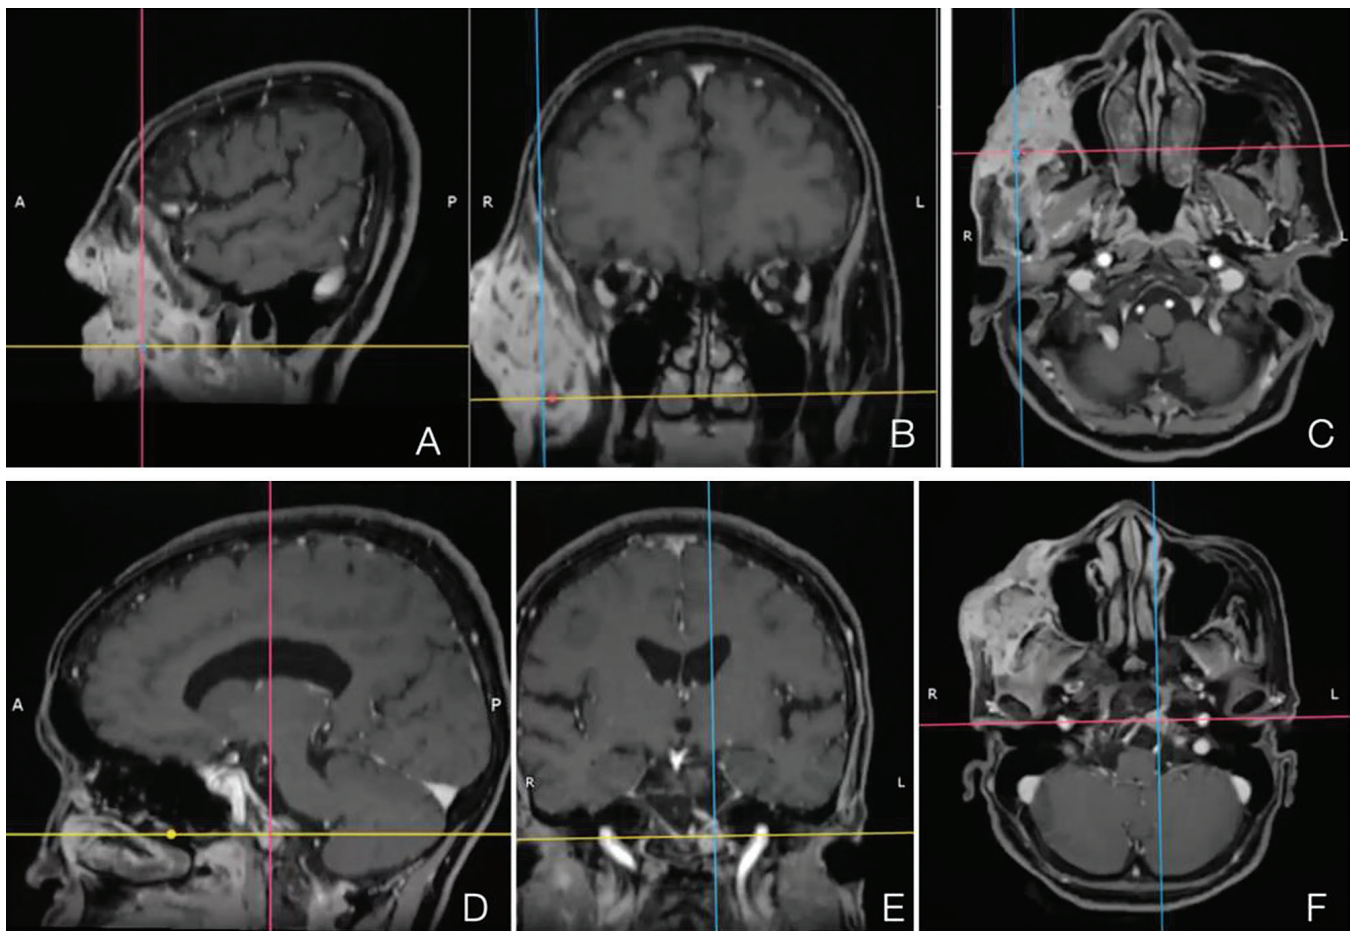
Contrast-enhanced cranial MRI. Sagittal (A), coronal (B), and axial (C) T1-weighted images showing extension of the mass to the masticator space. Sagittal (D), coronal (E), and axial (F) T1-weighted images showing heterogenous (predominantly hyperintense) signals in the left aspect of the clivus measuring approximately 1.0 x 1.0 x 1.0 cm (CC x W x AP). The focus is intimately related to the petrosal sinus.
